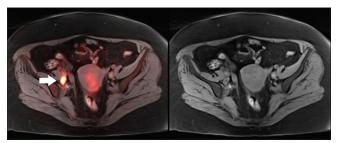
A 47-year-old female with squamous cell carcinoma of the exocervix. Positron-emission tomography-magnetic resonance fusion body sequence (left) showing a hypermetabolic right internal iliac lymph node (arrow) with SUV 14.8 which is enlarged on the T1-weighted radial volumetric interpolated breath-hold examination image (right). Mild heterogeneous uptake is noted in the uterine fundus due to benign fibroid activity
